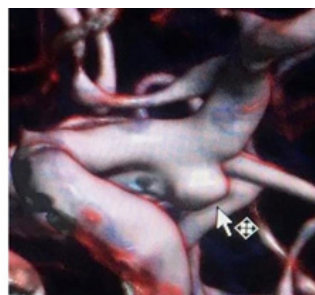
CT Angiography PCOM Aneurysm
